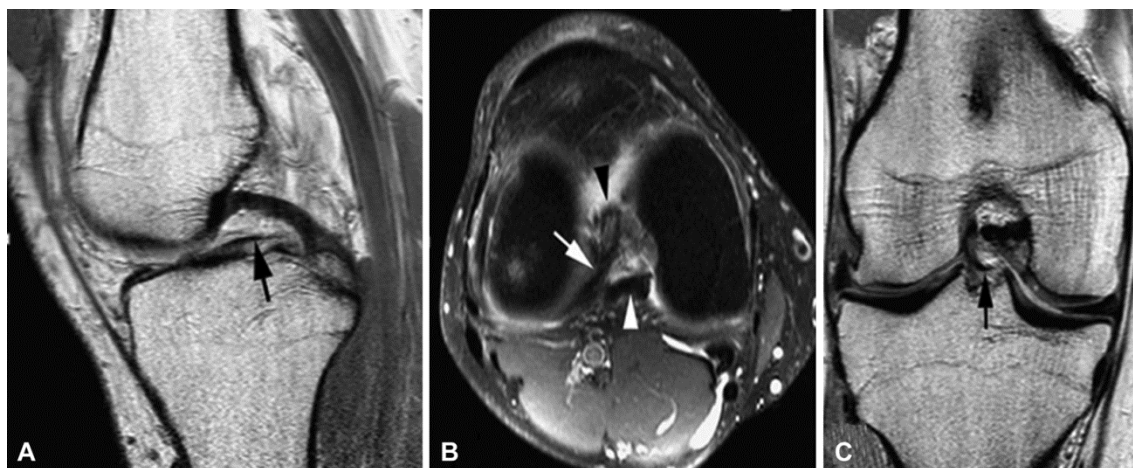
MRI scans of the right knee in a 35-year-old patient I. showing: A – sagittal view demonstrating linear structure susceptible of displaced meniscus; B – transverse view demonstrating hypointense oblique linear structure in intercondylar notch; C – coronal view demonstrating meniscus disconnected ligamentous structure (oblique intermeniscal ligament)
